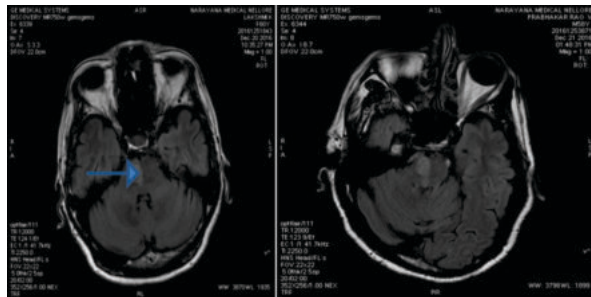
Brain stem infarct Axial FLAIR images showing infarct in the right hemi pons in two as a hyper intense area. (patients presenting with trigeminal neuralgia).
